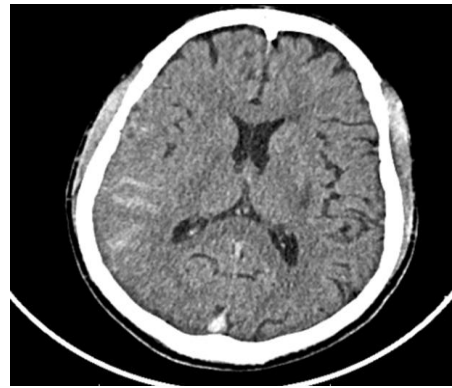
CT brain axial section shows subarachnoid hemorrhage in right frontal , parietal and temporal lobes
